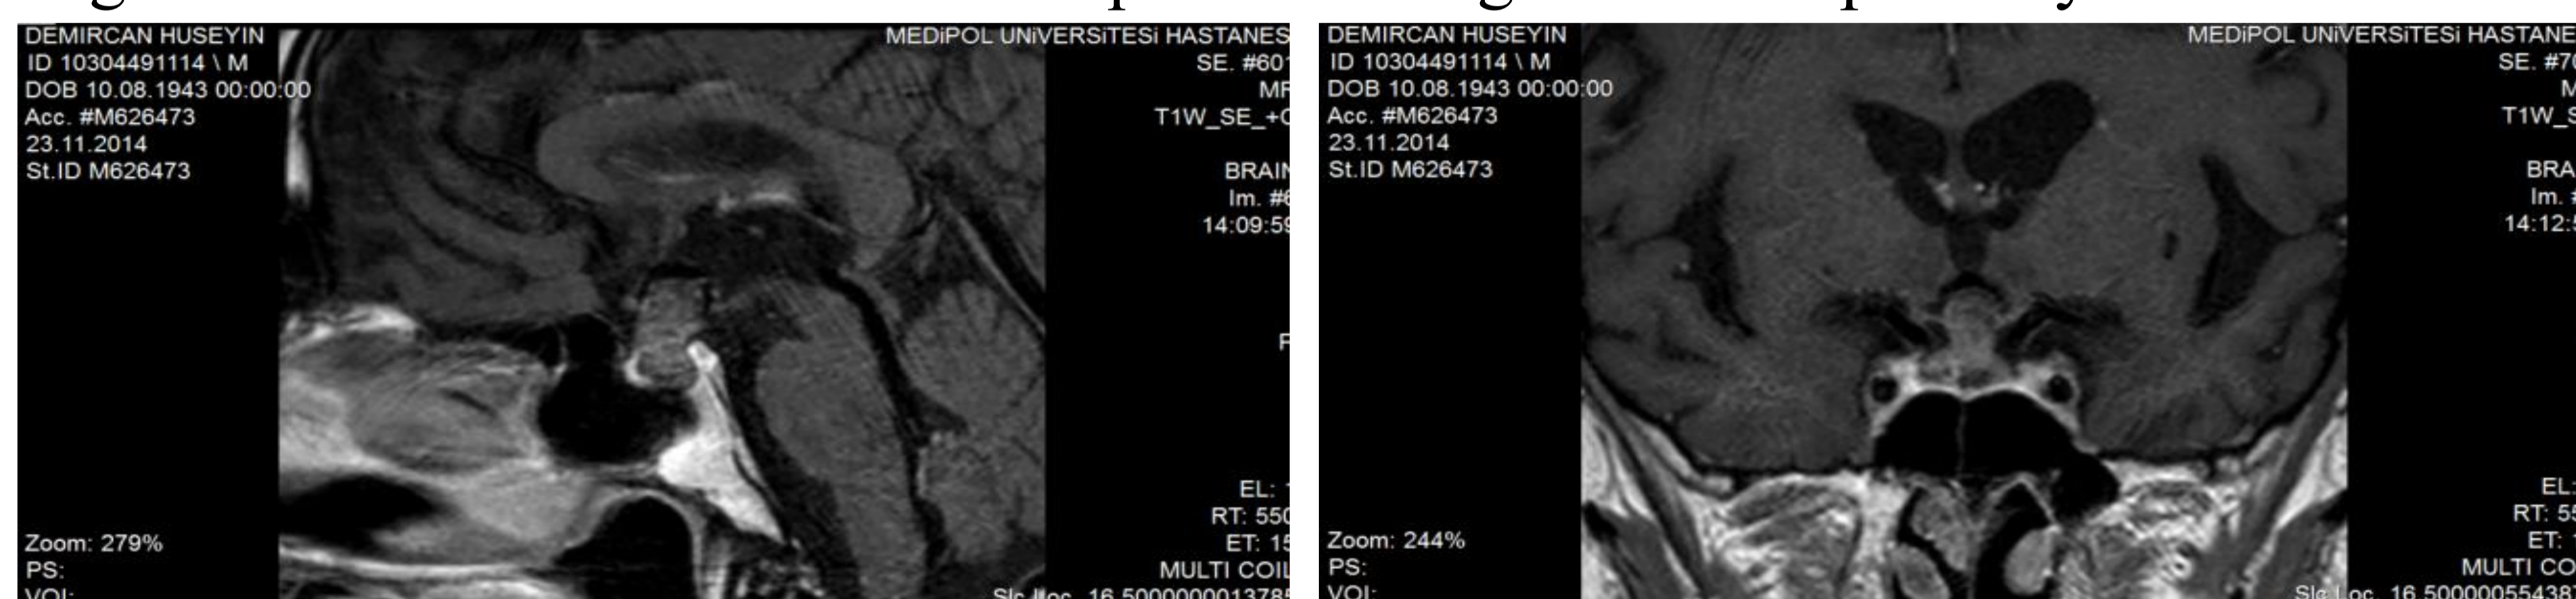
After RT, there is any treatment response on the last pituitary MRI.
